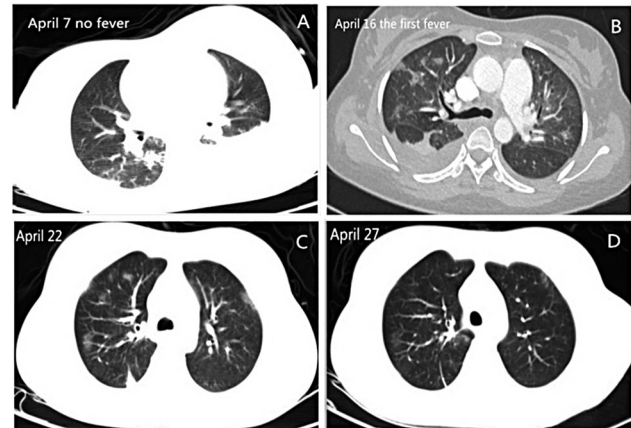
The change of chest CT after anti-infection treatment. The CT indicates pulmonary multiple seepage on admission (A). Chest CT shows the lung infection lesions along the blood vessels and mostly located at the end of the blood vessels (B). After anti-infection treatment, the chest CT gradually became normal (C and D).
